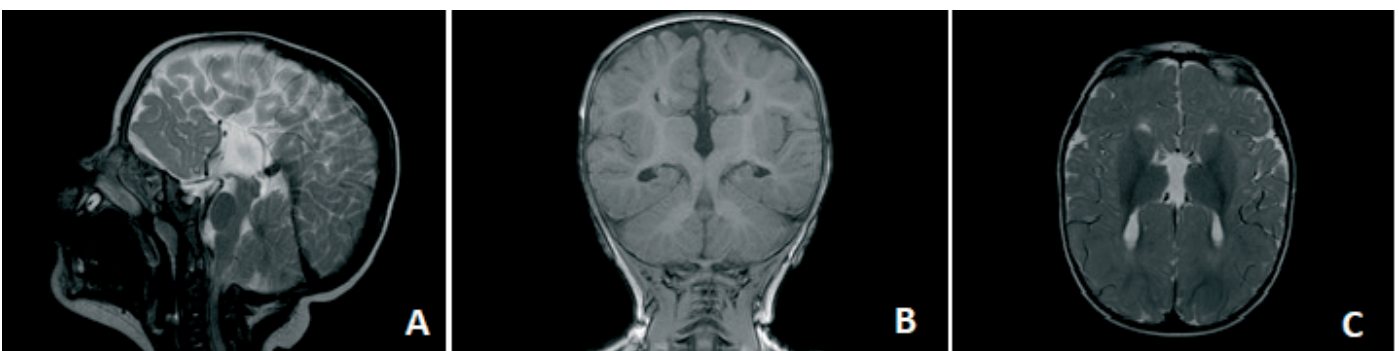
Magnetic resonance imaging image
